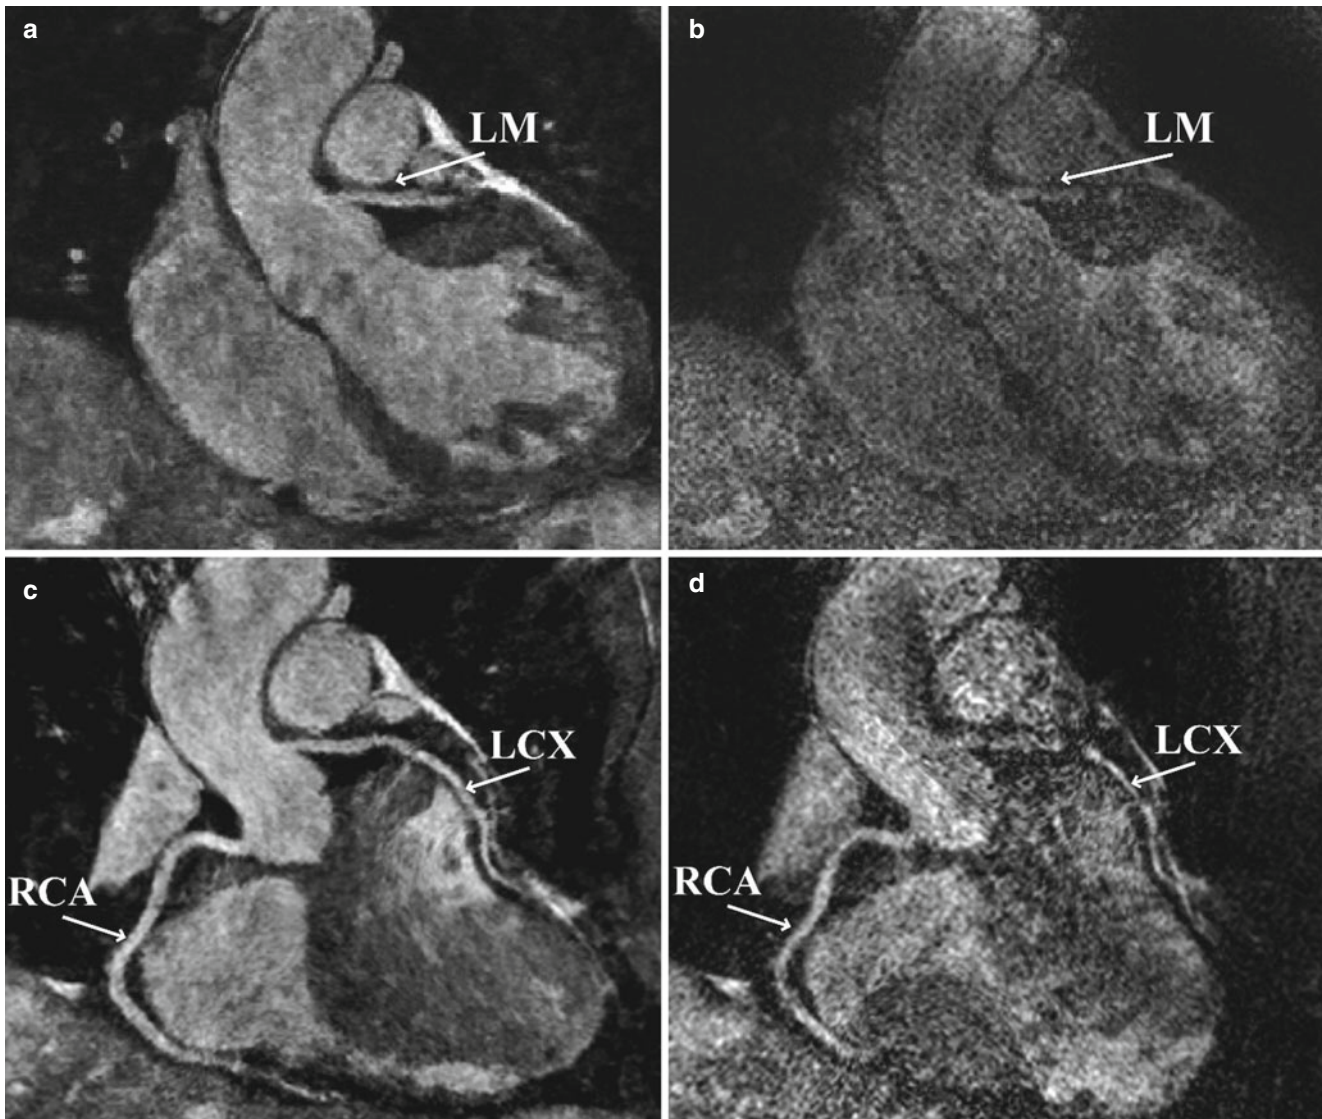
Example images from two separate highly-accelerated sub-millimeter resolution whole-heart coronary MRI. An example coronal slice (*top*) containing a cross-section of the left main (*LM*) shows that SENSE images, acquired with sixfold uniform undersampling (*right*), suffers from noise amplification. In contrast, the LM is clearly
